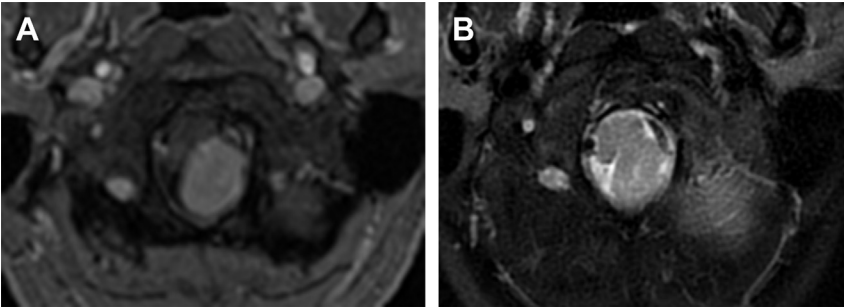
Schwannoma of CN XI. Axial (A) T1-weighted and (B) T2-weighted images show a uniformly enhancing lesion arising in the posterolateral foramen magnum with T2-weighted signal isointense to the brainstem. The tumor forms sharp angles with underlying bone, unlike the more common meningioma.
